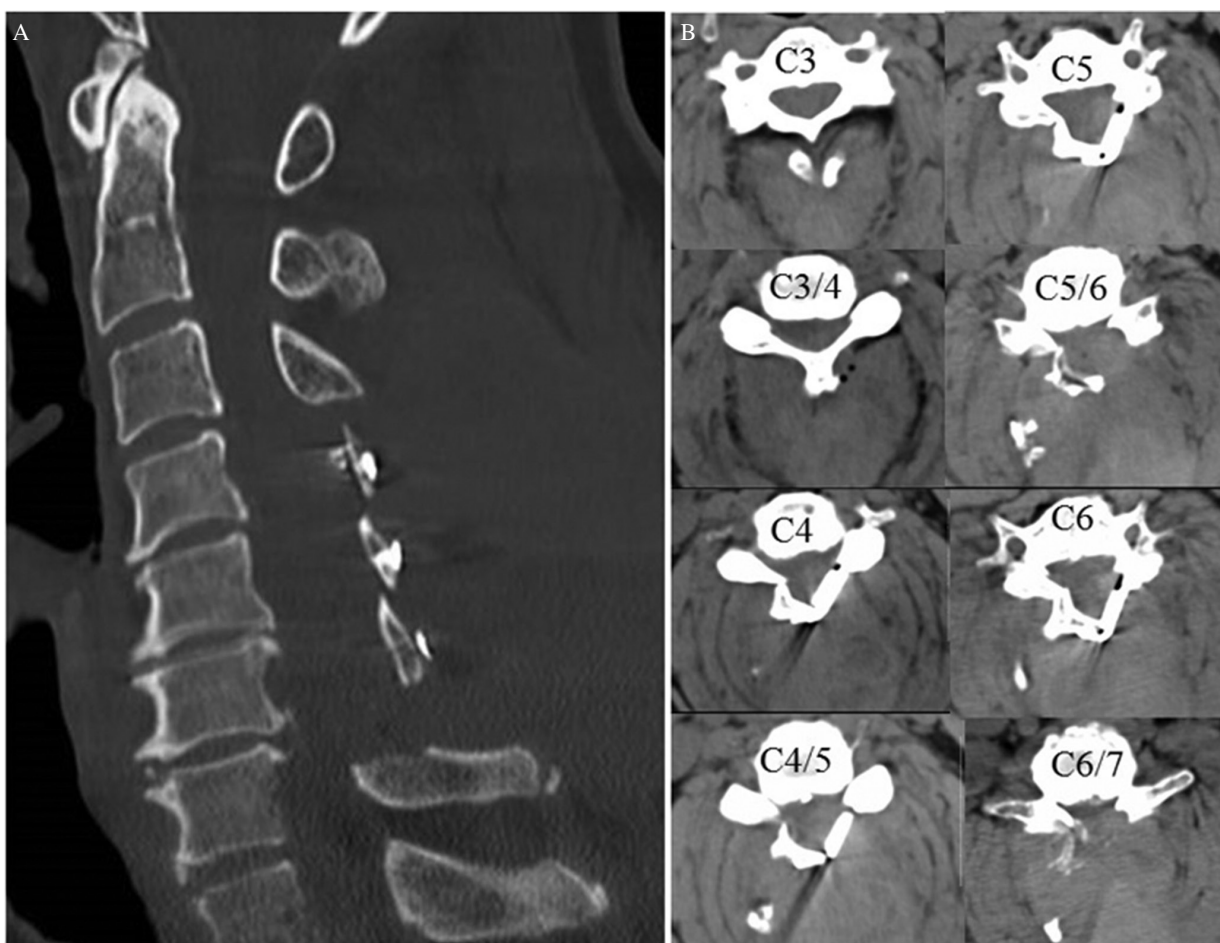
Postoperative CT scans obtained 7 days after cervical laminoplasty demonstrate a huge epidural and intramuscular hematoma compressing the spinal cord. (A) A sagittal image (bone window). (B) Axial images from C3 to C6/7 (soft-tissue window).
